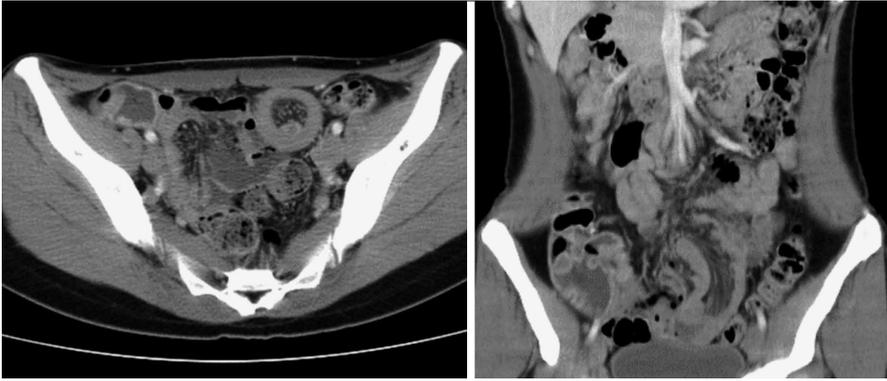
Computed tomography of abdomen: Computed tomography revealed an ileo-ileal intussusception. The leading point revealed hypovascular mass measuring 1 cm in a diameter.
